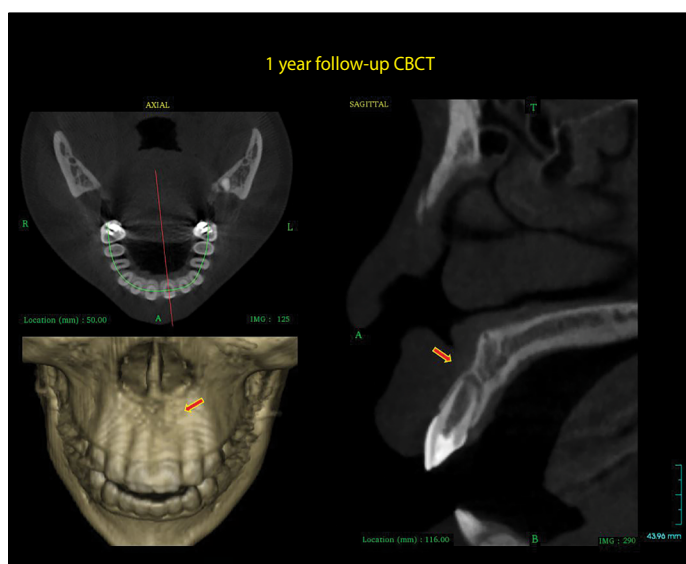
Postoperative CBCT. (a) Cross-sectional view within intersection transverse line on the midline of the left maxillary central incisor. (b) 3D reconstruction image shows the labial cortical plate at the apical part of the root. (c) Sagittal view image reveals labial cortical plate formation and incomplete healing of the apex of the tooth
